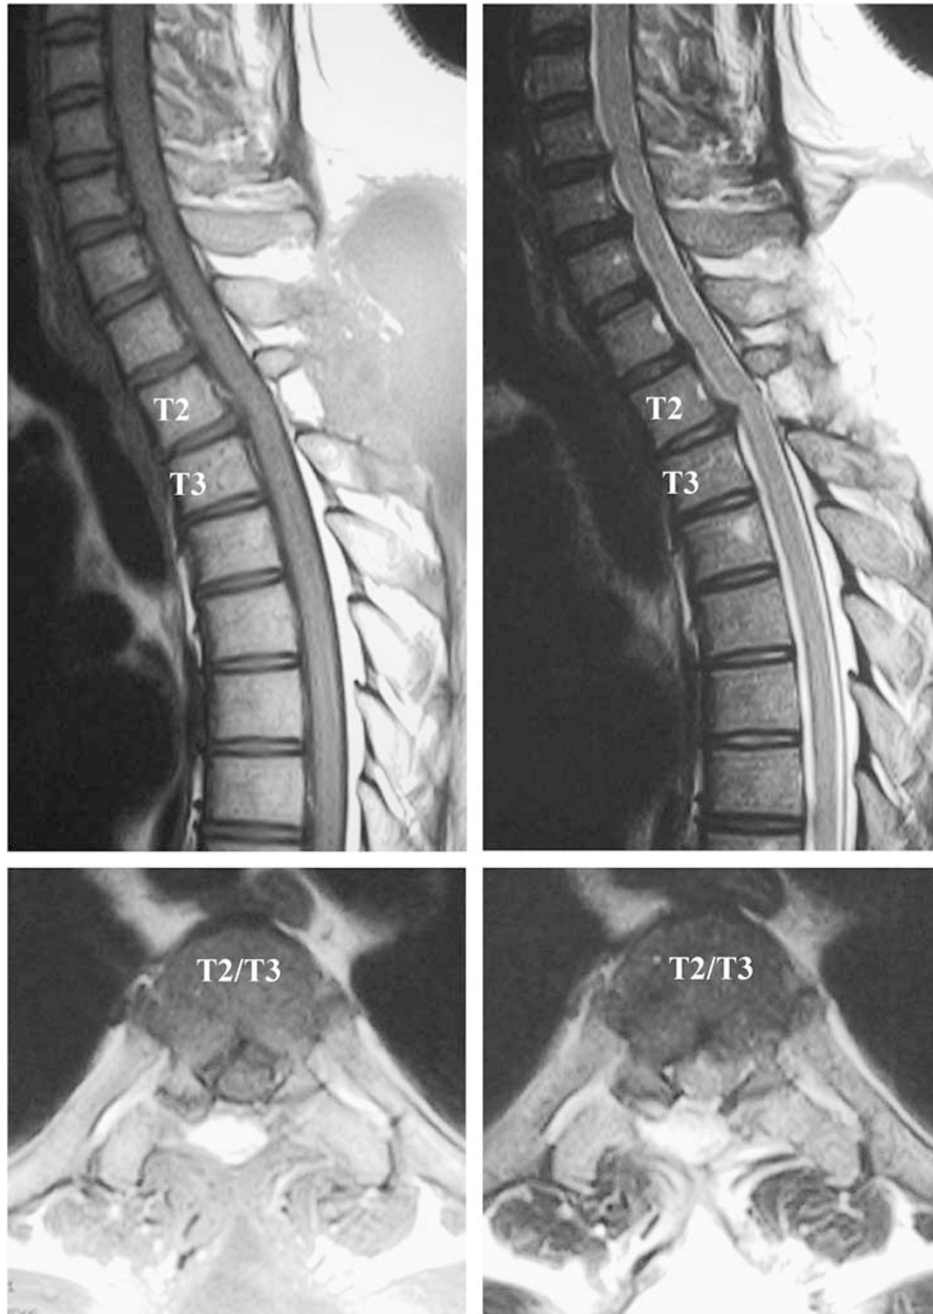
Magnetic resonance images made postoperatively, showing slight posterior bulging at T2–T3 level. However, there was no residual spinal cord compression. sagittal T1 weighted (upper left), T2 weighted (upper right), axial T1 weighted (lower left) and T2 weighted (lower right)
